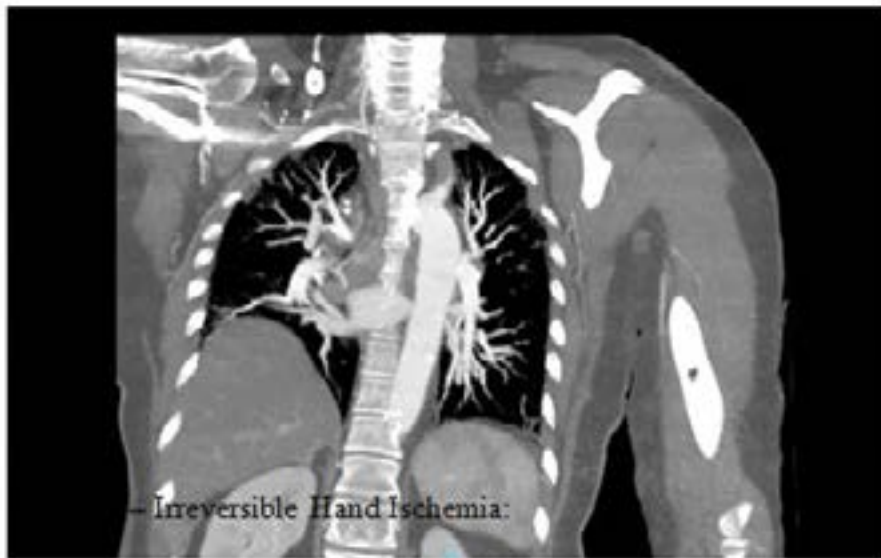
Angio-CT SCAN with subclavian artery occlusion in CASE 2
